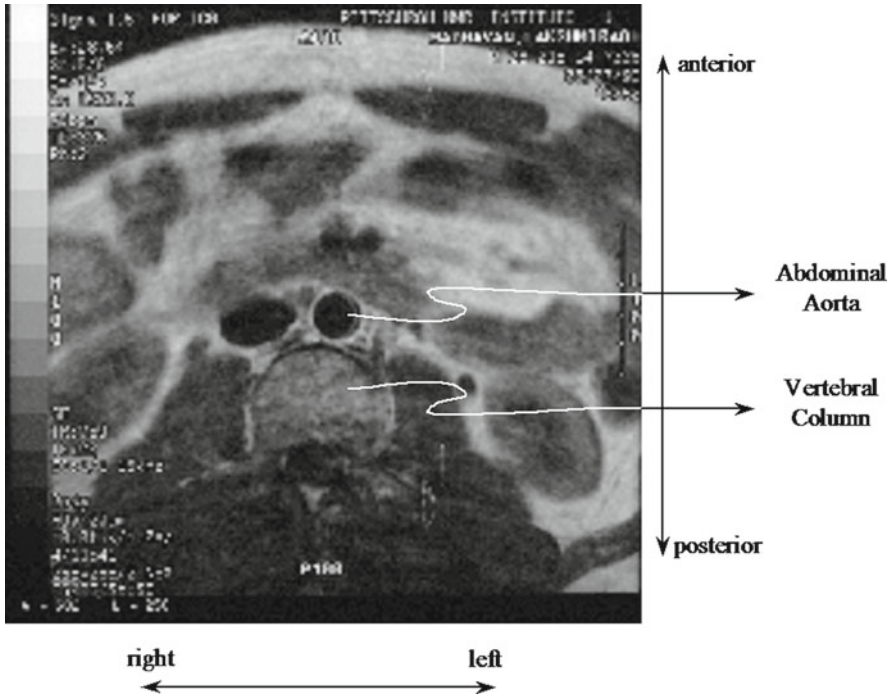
MRI of normal infrarenal abdominal aorta
